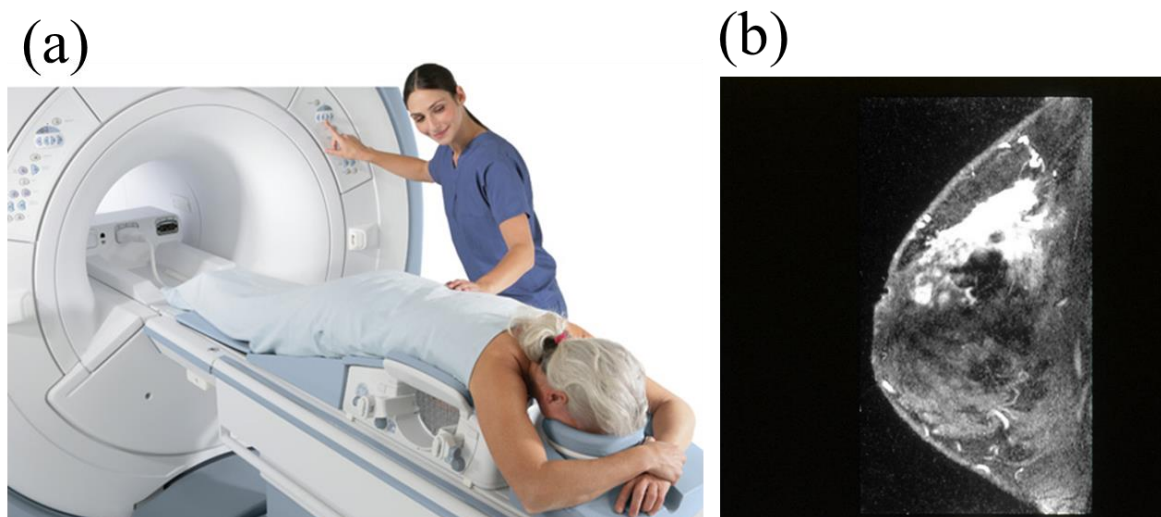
(a) MRI Equipment, (b) MRI of individual breast, demonstrating marked enhancement (bright area) which was confirmed to be cancer (National Cancer Institute, February 1994)
